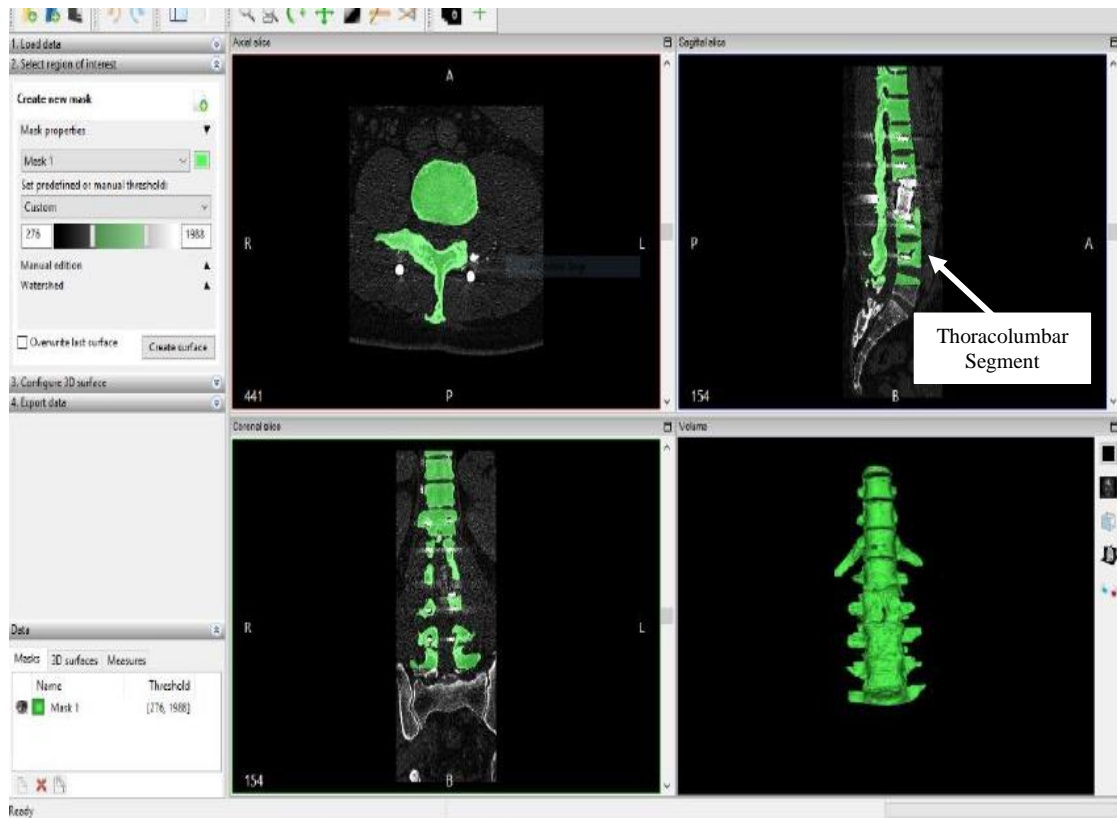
CT Scan of Thoracolumbar Segment
